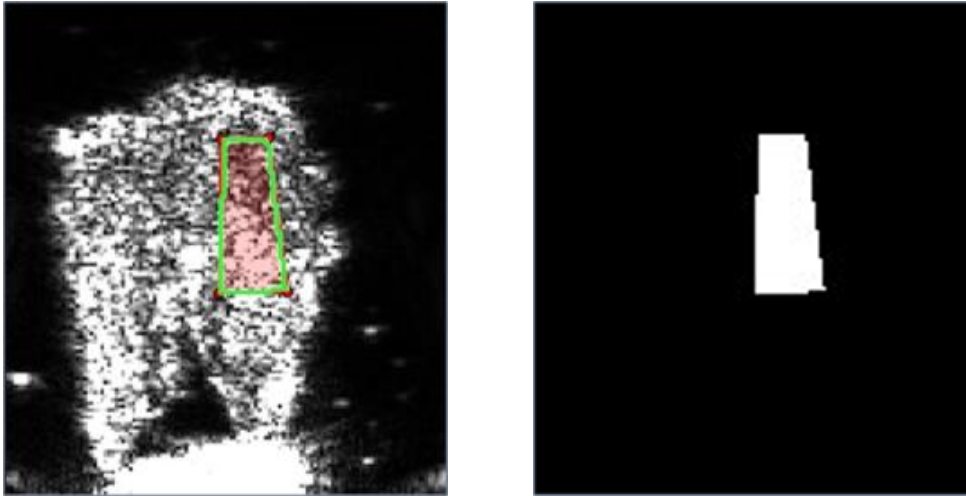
Images of manual mask (right) and corresponding B-mode US data (left). On the mask image (right), the white region is the stromal area of the prostate which was determined by the manual annotation on the B-mode ultrasound image (left).
